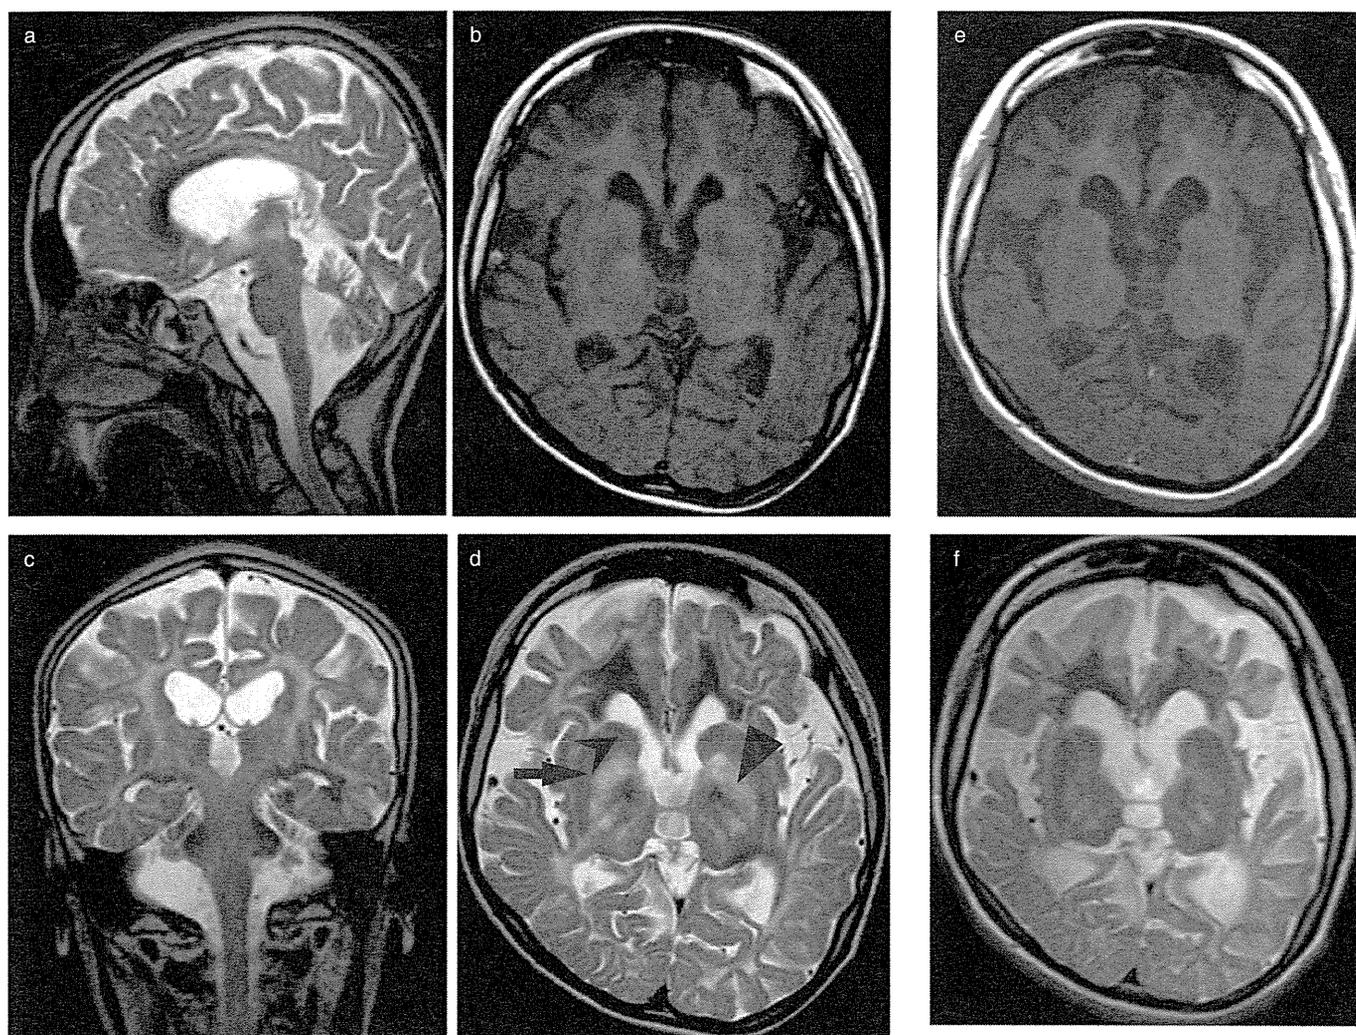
Chronological features of magnetic resonance imaging (MRI) in a female Japanese Canavan disease patient at (a–d) 15 years and (e,f) 25 years of age. (b,e) T1 and (a,c,d,f) T2-weighted MRI show the involvement of the diffuse white matter, including the corpus callosum and internal capsule, as well as the (▶) globus pallidus. The (↔) putamen and (▶) caudate nucleus were spared. There are signs of diffuse cerebral and cerebellum atrophy.
